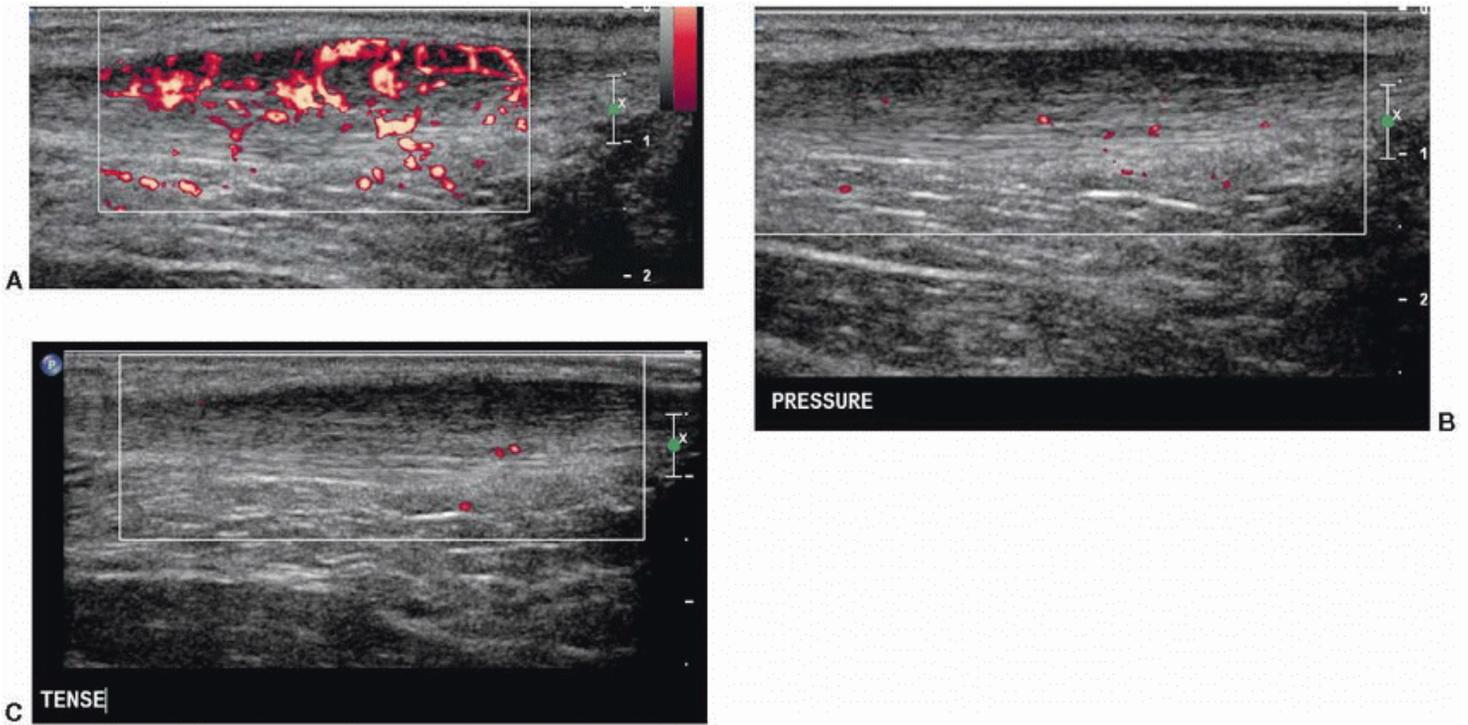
A: Power Doppler longitudinal scan showing typical Achilles tendinosis. There is fusiform thickening of the tendon, its superficial fibers are hypoechoic, and there is extensive neovascularity in the tendon and adjacent soft tissues. B: Heavy pressure has obliterated the Doppler signal. C: Putting the tendon under tension by dorsiflexing the foot has also abolished the Doppler signal.
